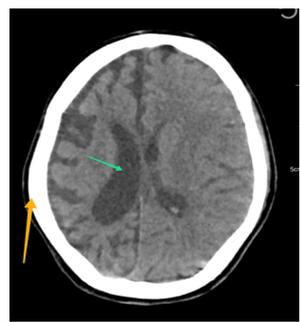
CT scan of brain showing right cerebral hemiatrophy, midline shift to the right, right ventricular dilatation (green arrow) and right calvarial thickening (yellow arrow)
